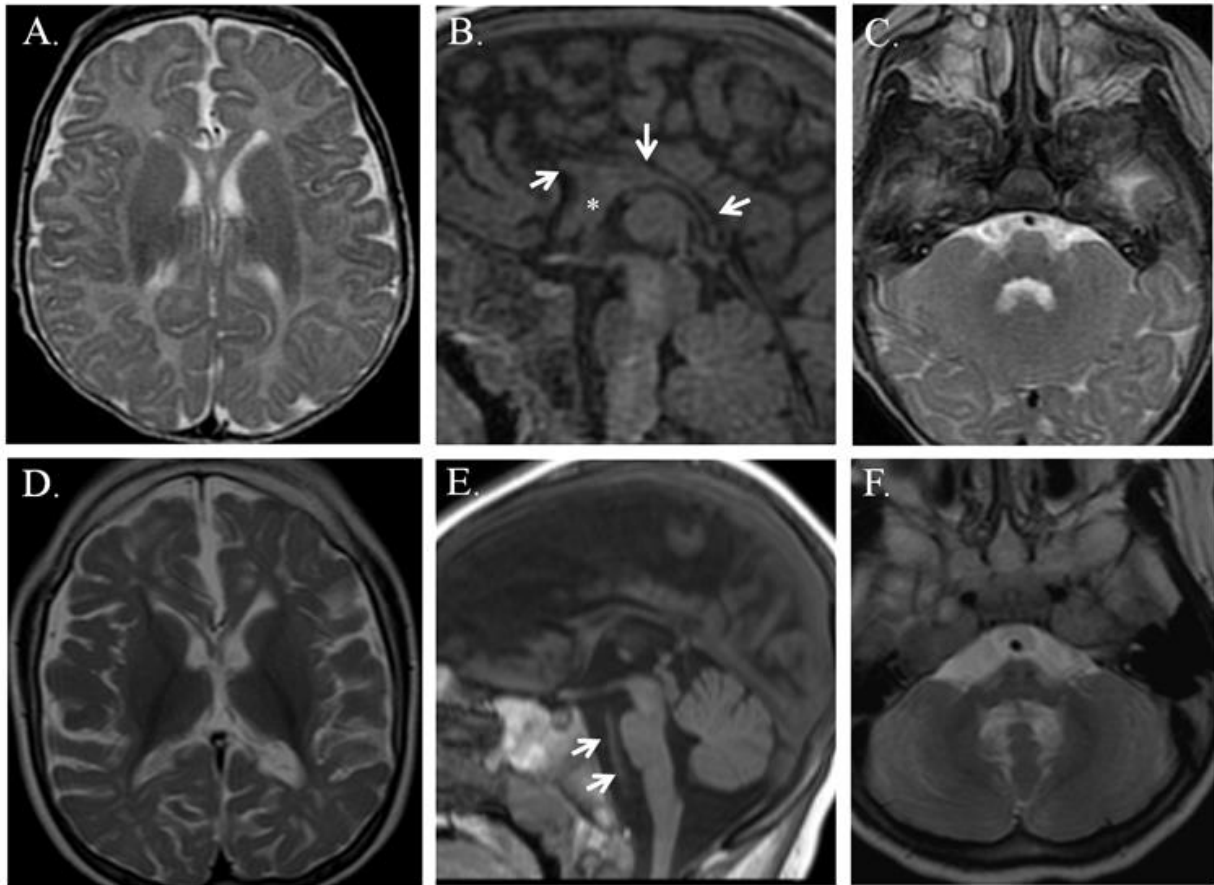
Baseline Magnetic Resonance Imaging (MRI) examination performed at 3-months (A,B,C). A: Axial T2-weighted image showed a diffuse slight hyperintensity of biemispheric white matter related to hypomyelination. B: Sagittal T1-weighted Magnetization-Prepared Rapid Gradient Echo (MP-RAGE) image well depicted the severe hypoplasia of the corpus callosum (arrows); the anterior commissure is enlarged (asterisk). C: Axial T2-weighted image showing a quite normal appearance of posterior fossa structures. Follow-up MRI examination at the age of 4 years (D, E, F). D, F: Axial T2-weighted images showing gray matter/white matter volume loss at both supratentorial and infratentorial region. E: Sagittal T1-weighted MP-RAGE image better depicts brainstem atrophy with enlargement of the cisternal spaces (arrows).
